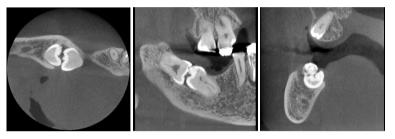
CBCT images: Right mandibular second and third molars were in contact with occlusal surfaces in a single follicular space with roots pointing in opposite directions.
